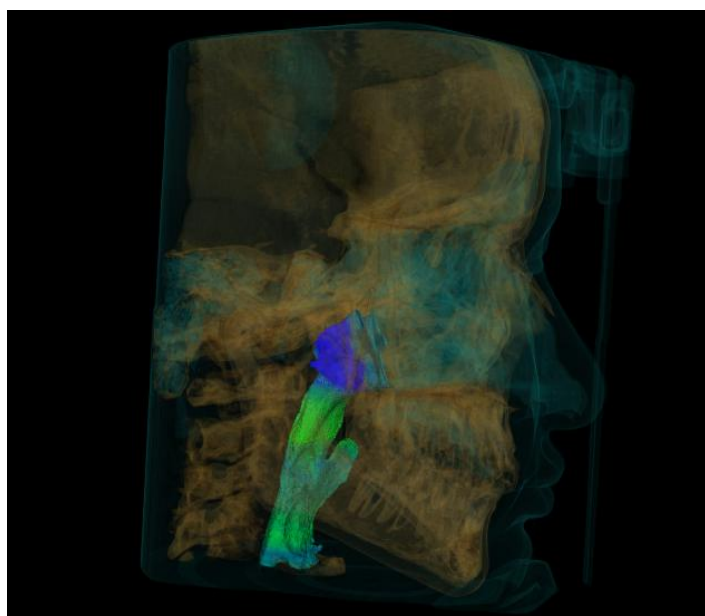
Sagittal Three-Dimensional Cone Beam Computed Tomography (CBCT) image of class I upper airway anatomy presents a patient's upper airway anatomy with a Class I skeletal relationship, characterized by ordinary anteroposterior alignment in the maxilla and mandible.
